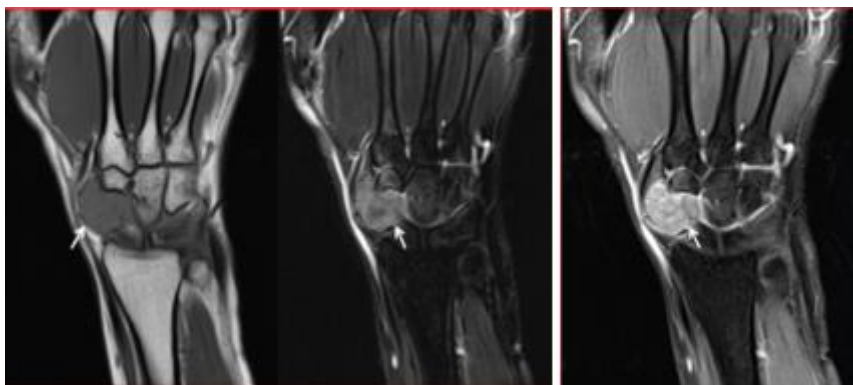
Coronal image of the wrist showing a lobulated soft-tissue mass along the radial aspect of the wrist (arrow). The lesion appears hypointense on T1-weighted imaging, demonstrates heterogeneous hyperintensity on T2 image and shows avid heterogeneous enhancement on post-contrast fat-suppressed T1-weighted images, consistent with a Giant cell tumor of tendon sheath.
